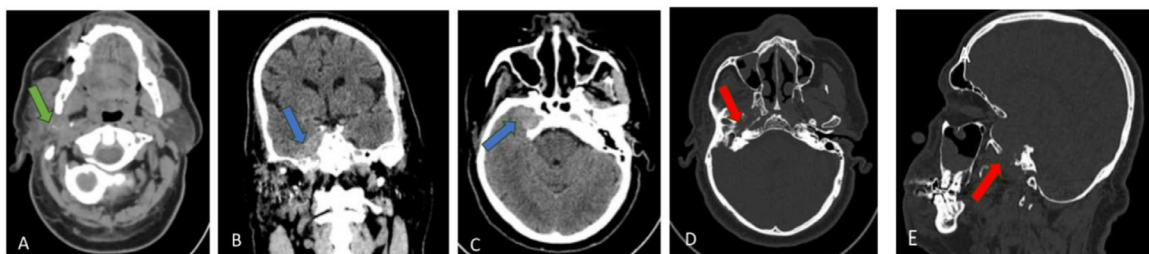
Initial brain CT without contrast in multi planes presented in mediastinum (A) brain (B,C) and bone (D,E); (A) Enlargement of right parotid gland lesion with extension to the superficial lobe (green arrow), (B & C) Intracranial soft tissue dense lesion at the right temporal region (blue arrow), (D & E) Bone destruction at right greater wing of sphenoid (red arrow).
